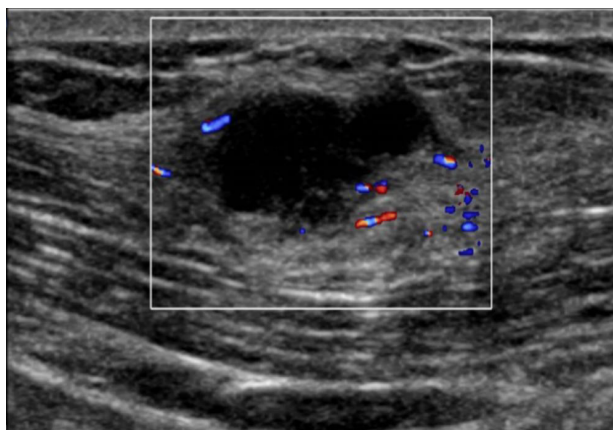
Ultrasound scan showing a hypoechoic cystic lump lying deep to external oblique aponeurosis.
